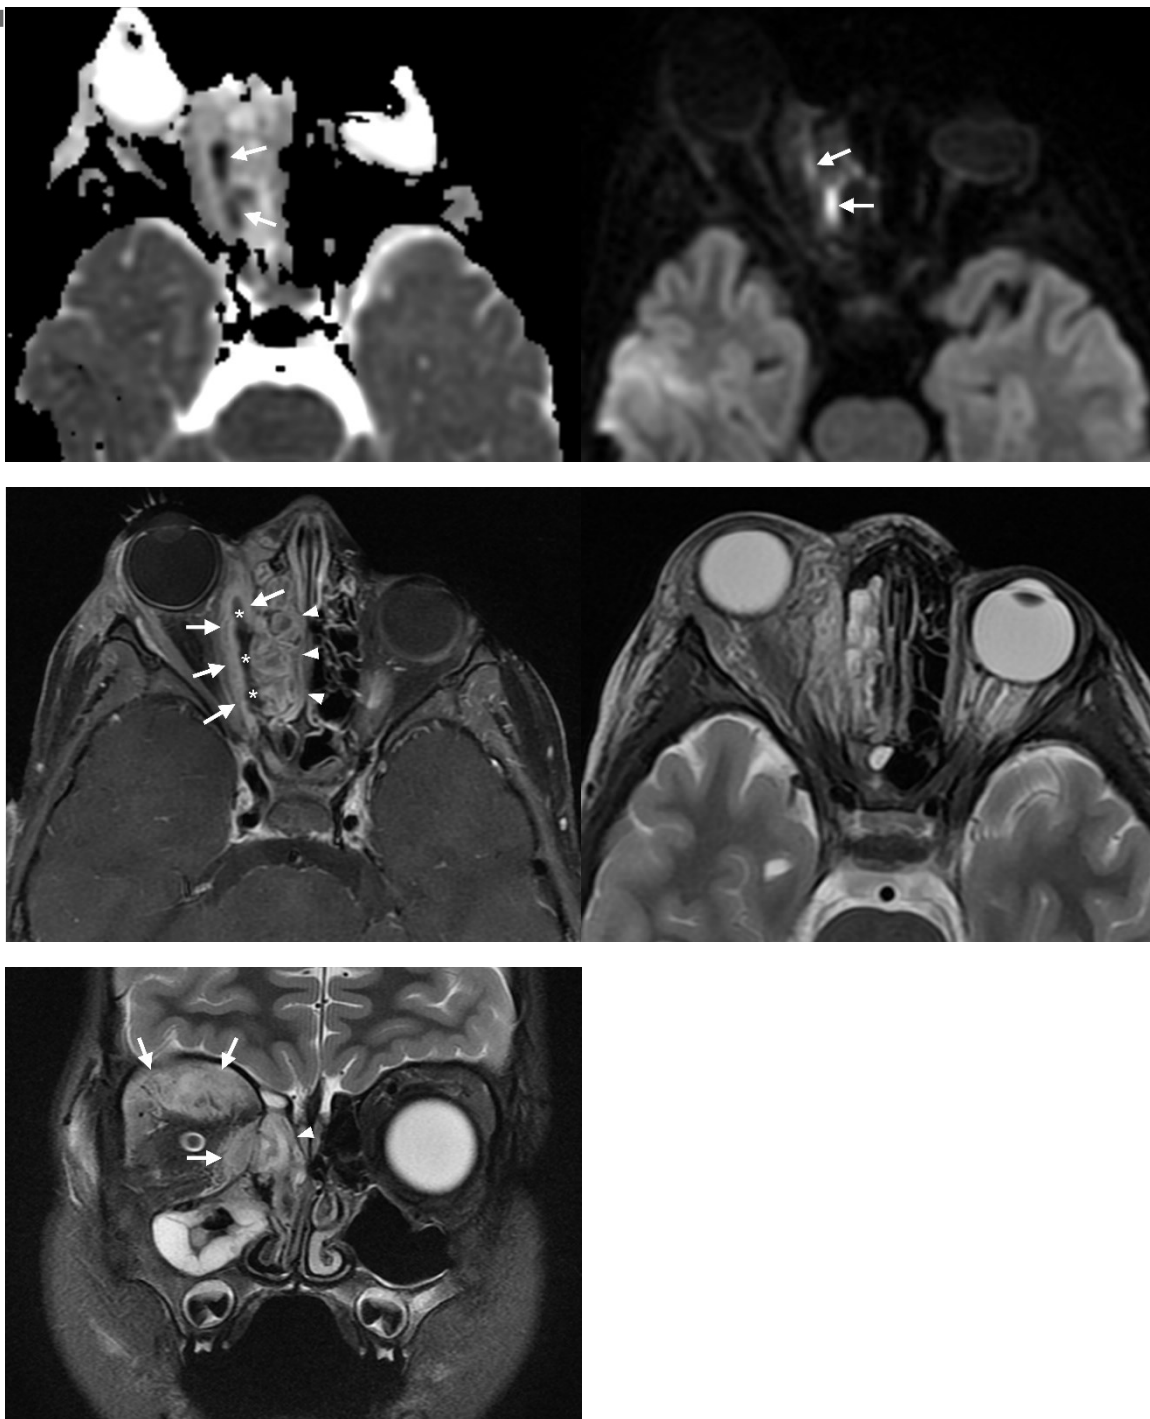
4-year-old male with orbital cellulitis associated with ethmoid sinusitis. Fat-suppressed T2-weighted coronal images (A) show high signal intensities (arrows) consistent with cellulitis secondary to right ethmoid sinusitis (arrowheads). Conventional T2-weighted axial image (B) shows high signal intensities in the bilateral infraorbital regions, complicating detailed evaluation of inflammatory spread. Contrast-enhanced fat-suppressed T1-weighted image (C) shows irregular enhancement at the margin (arrows) and lack of enhancement (*) in the right orbital subperiosteum. There is enhancement (arrowheads) with mucosal thickening of the right ethmoid air cells. The right orbital lesion shows high signal (arrows) on diffusion-weighted imaging (D) and low signal (arrows) on apparent diffusion coefficient (ADC) map (E), indicating diffusion restriction consistent with abscess formation. The ADC value is $0.56 \times 10^{-3} \text{mm}^2/\text{s}$.
